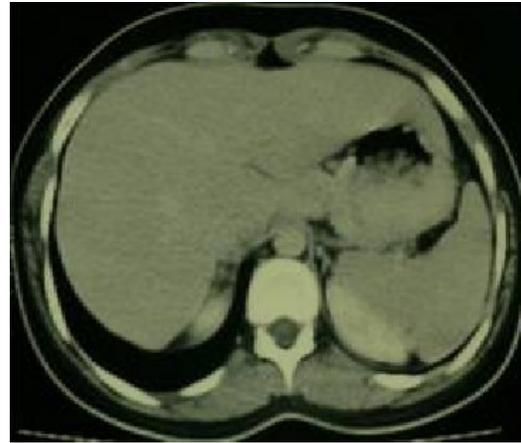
Axial contrast enhanced CT scan image of the upper abdomen showing thickening of the wall of gastric cardia with large fungating mass protruded into the lumen of the stomach.
